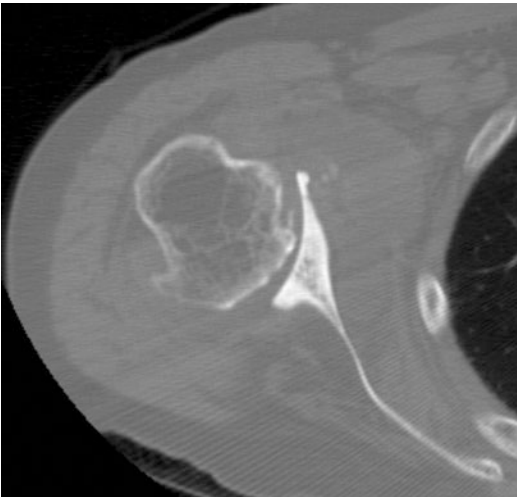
Axial CT scan of patient with a Walch B3 glenoid
